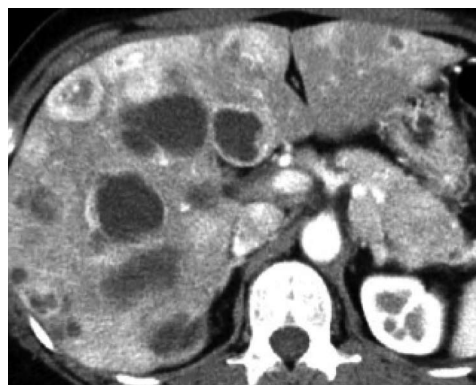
Abdominal enhanced computed tomography showed a contrast-enhanced tumor lesions accompanied by cystic changes in the liver and the pancreatic tail.
